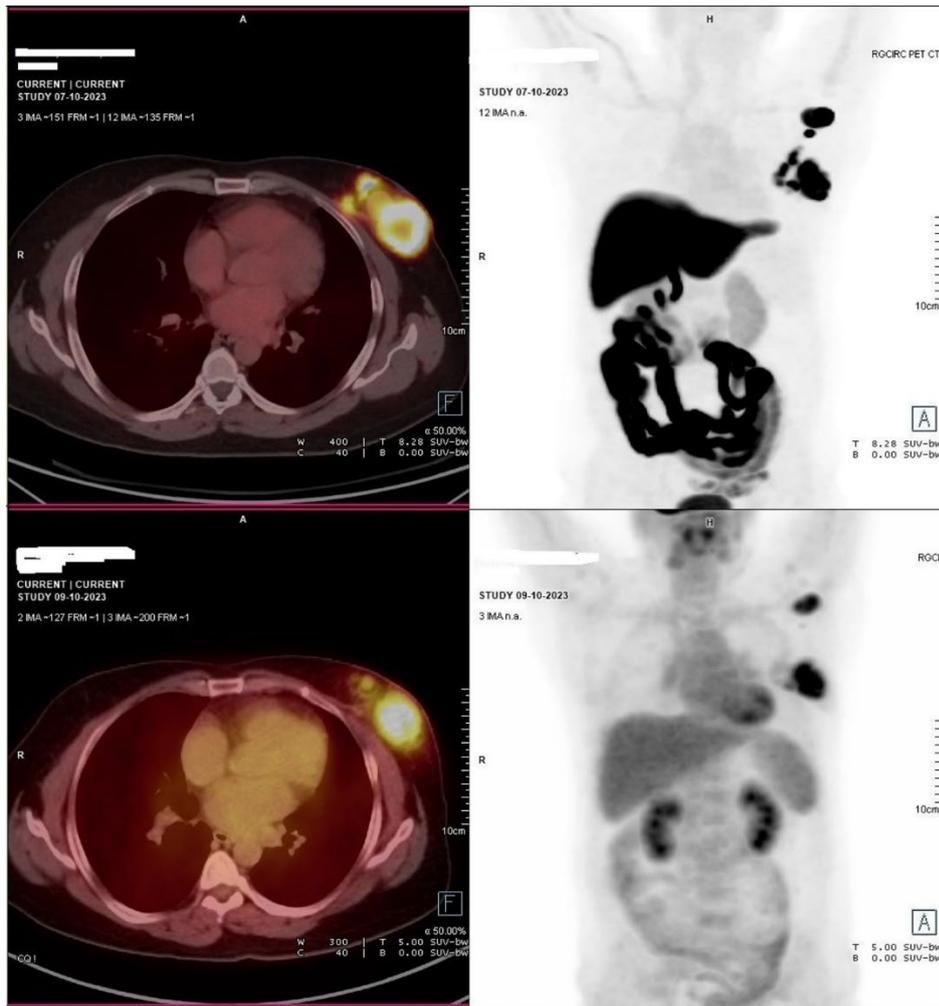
A 50-year-old case of invasive breast carcinoma on the left side with axillary lymphnodal metastasis. ER=100% expression: strong. $[^{18}\text{F}]$ FES scan shows FES avid breast lesion and axillary lymph nodes, more in avidity and number than the $[^{18}\text{F}]$ FDG study.
